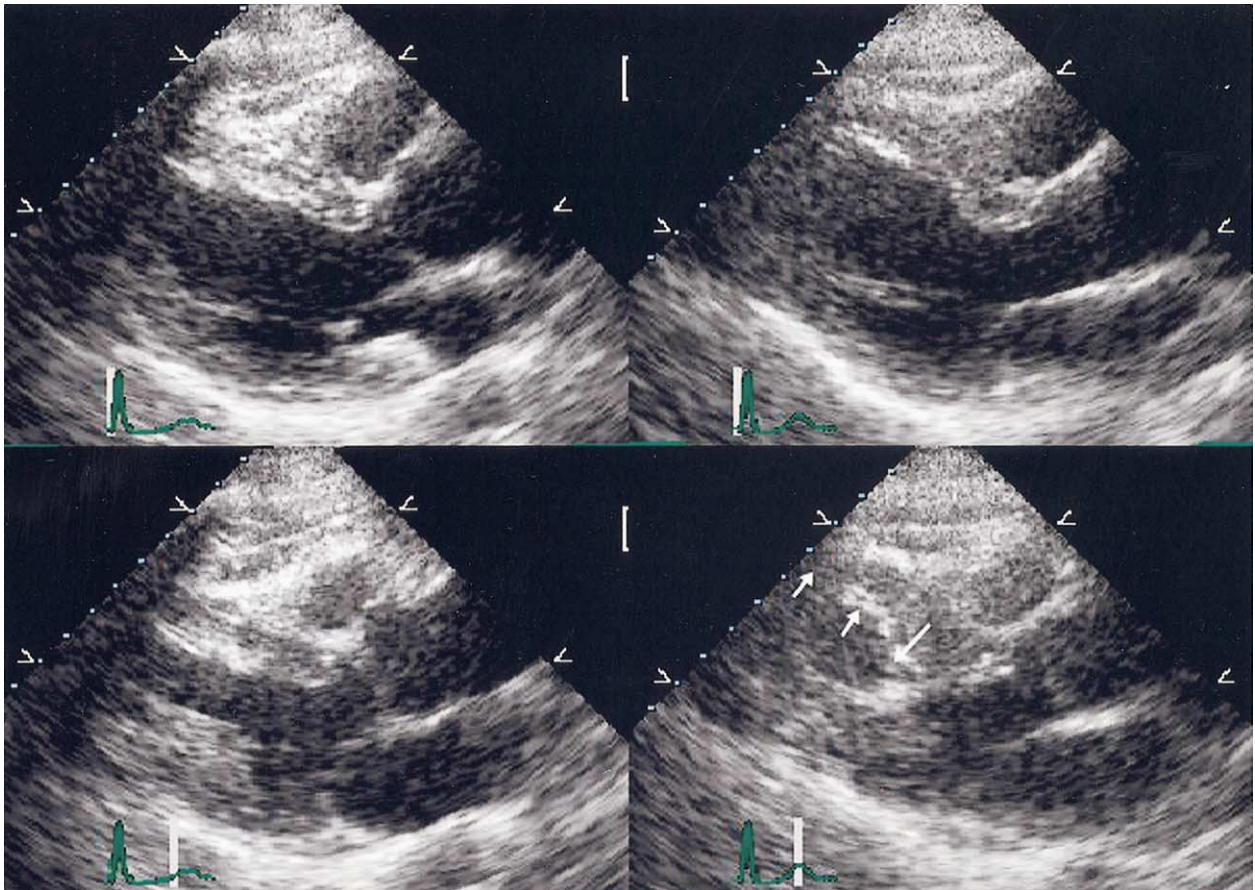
Parasternal long-axis echocardiogram recorded at rest (left) and immediately after exercise (right) in a patient with stenosis of the left anterior descending coronary artery. Diastolic frames are on the top, and systolic frames are on the bottom. At rest, notice the normal contraction of the septum and posterior wall. Immediately after exercise, the proximal septum has normal contractility (downward pointing arrow), and there is dyskinesia of the distal ventricular septum (upward pointing arrows).
